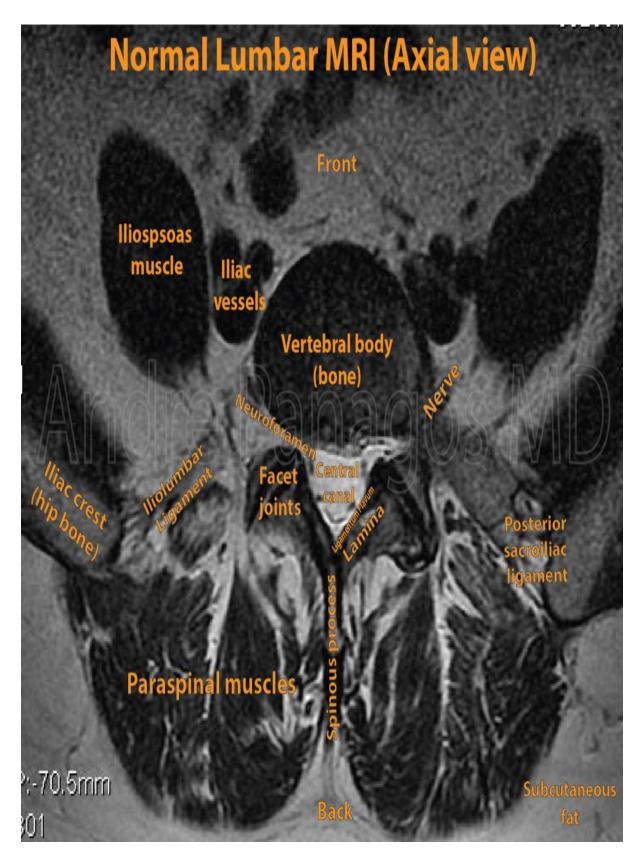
normal lumbar MRI; Axial view
